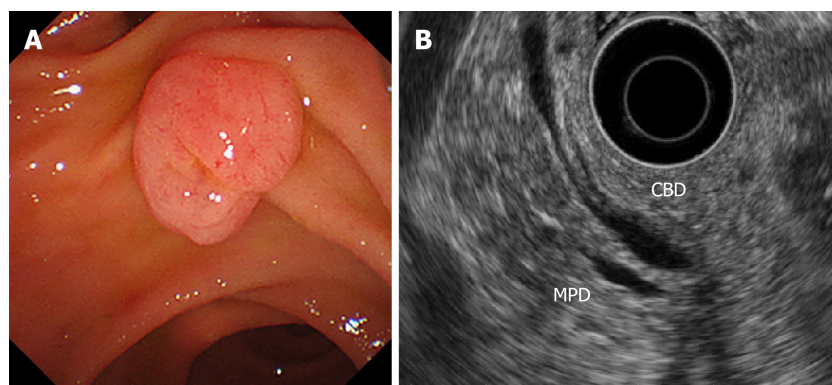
A case of ampullary adenoma that was indicated for endoscopic papillectomy. A: Duodenoscopy showed an ampullary tumor. The tumor was diagnosed as an adenoma based on an endoscopic biopsy. B: Endoscopic ultrasound did not show any bile/pancreatic duct invasion. CBD: Common bile duct; MPD: Main pancreatic duct.
